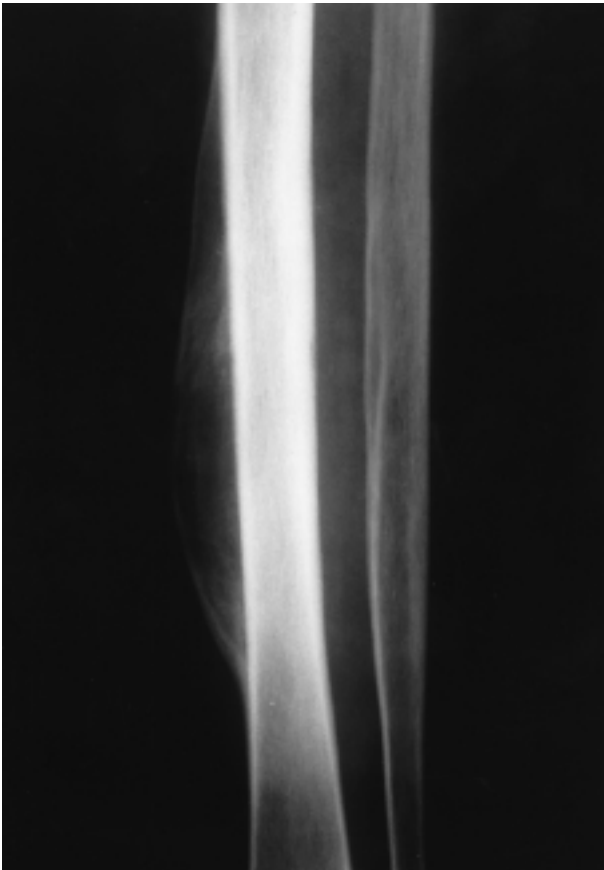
Anteroposterior xray of the left lower leg shows an elliptical periosteal elevation, with hour-glass appearance, typical of subperiosteal hematoma.
